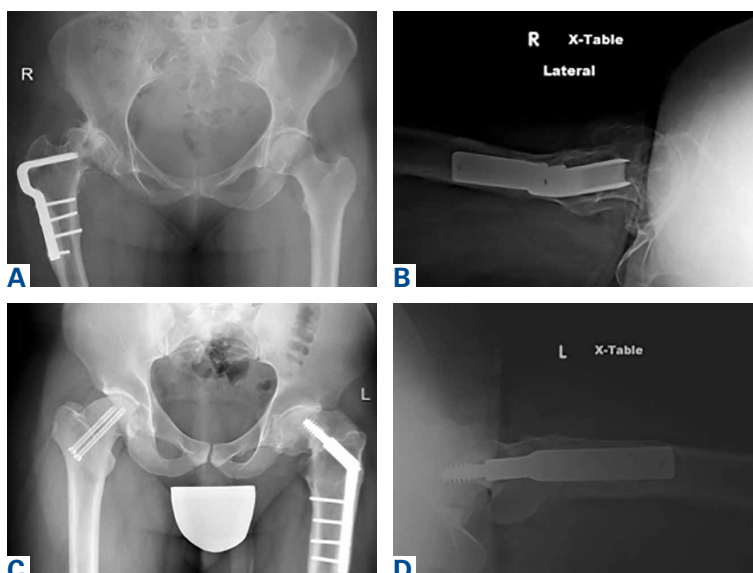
Preoperative (A) case 1 anteroposterior radiograph of pelvis, (B) case 1 cross-table lateral radiograph of left hip, (C) case 2 anteroposterior radiograph of pelvis, and (D) case 2 cross-table lateral radiograph of right hip.
